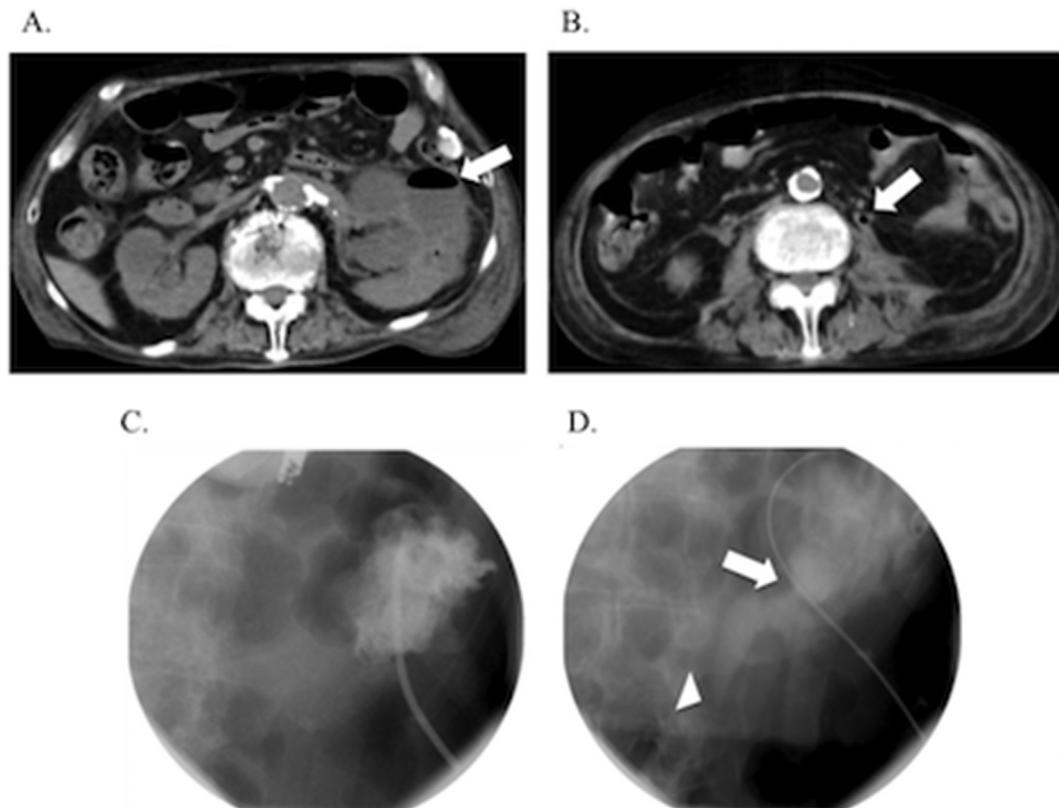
Computed tomography images of left-sided hydronephrosis and gas formation in the left kidney cysts (A) and ureter (B). Urography of the left renal cyst (C). Connection between the cyst and left renal pelvis (arrow) and obstruction of the left urinary tract (arrowhead) (D).
